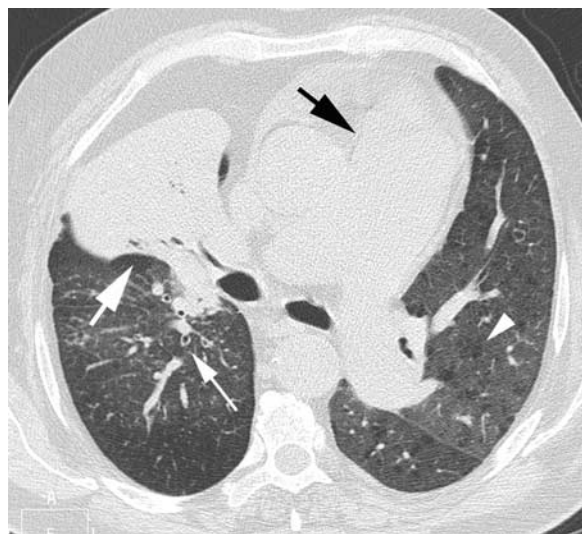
Lobar consolidation. HRCT of a 52-year-old man with emphysema shows a homogenous lobar consolidation in the middle lobe (arrow). Note the presence of air bronchograms within the consolidation, thickening of the bronchial walls (thin arrow), and severe pulmonary hypertension (black arrow). Sputum culture produced a heavy growth of *Moraxella catarrhalis*. HRCT indicates high-resolution CT.
